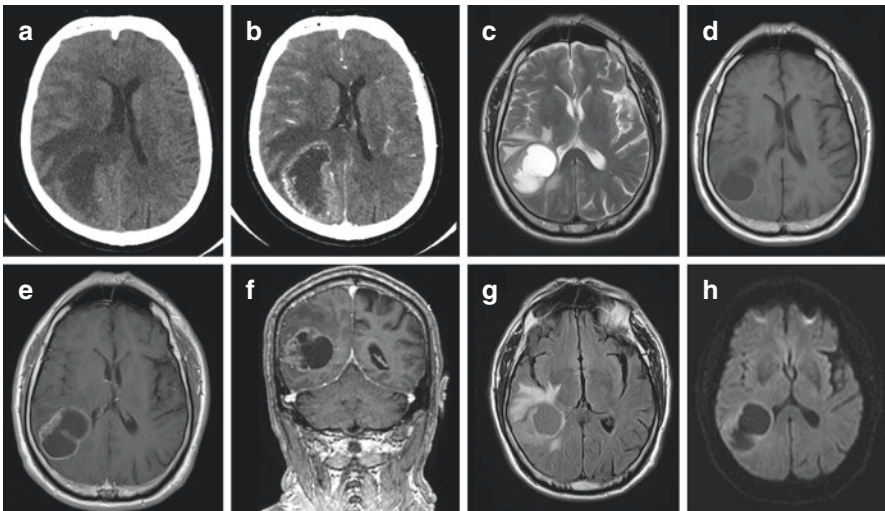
(a)–(h) Glioblastoma (Grade IV): (a) Axial pre-contrast CT scan; (b) Axial post-contrast CT scan; (c) Axial T2-weighted MRI scan; (d) Axial T1-weighted non-contrast; (e) Axial T1-weighted post-gadolinium; (f) Coronal T1-weighted post-gadolinium; (g) Axial MRI FLAIR; (h) Axial MRI DWI
